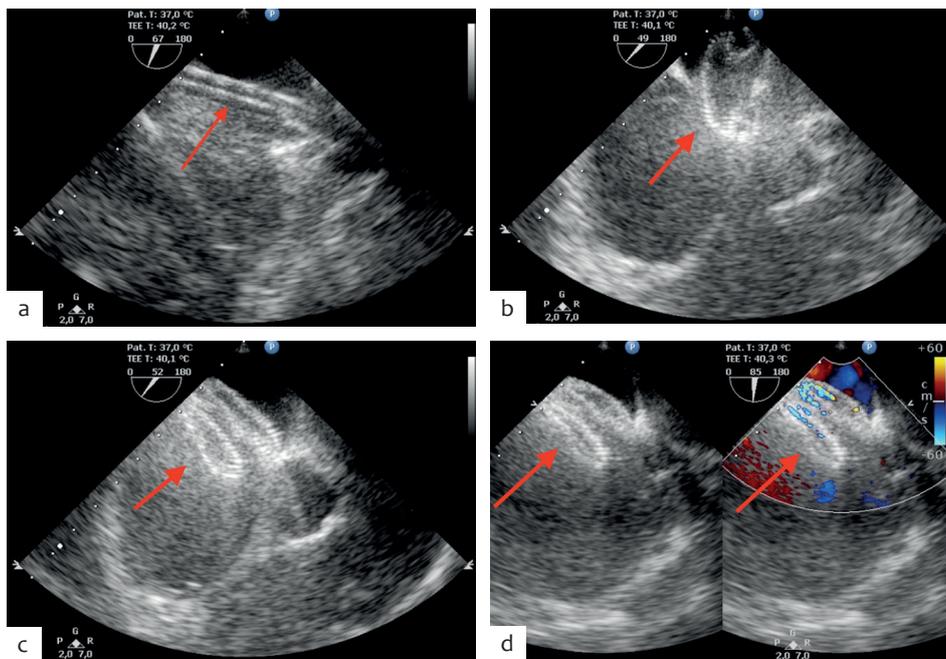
Transcatheter closure of ASD using TEE guidance (red arrow). (a) The delivery sheath was advanced to the LUPV; (b) the device was not fully occluding the defect, need repositioning; (c) after repositioning, the device was positioned correctly (no residual leak or impingement on adjacent structures); (d) TEE after the procedure showed the device stowed in place; no peripheral residual shunt was present (red arrow). ASD=atrial septal defect; TEE=transesophageal echocardiography; LUPV=left upper pulmonary vein
